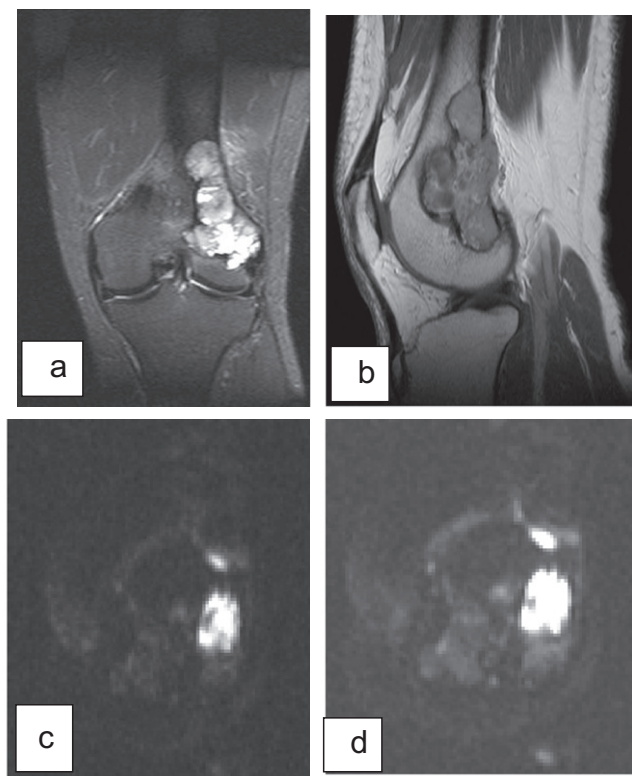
GCT of the distal femur appears of high signal in coronal fat suppression (a), low signal in sagittal T1WIs (b). No restriction in DWI (c, d) and ADC. ADC Value 1.2 ± 0 .
